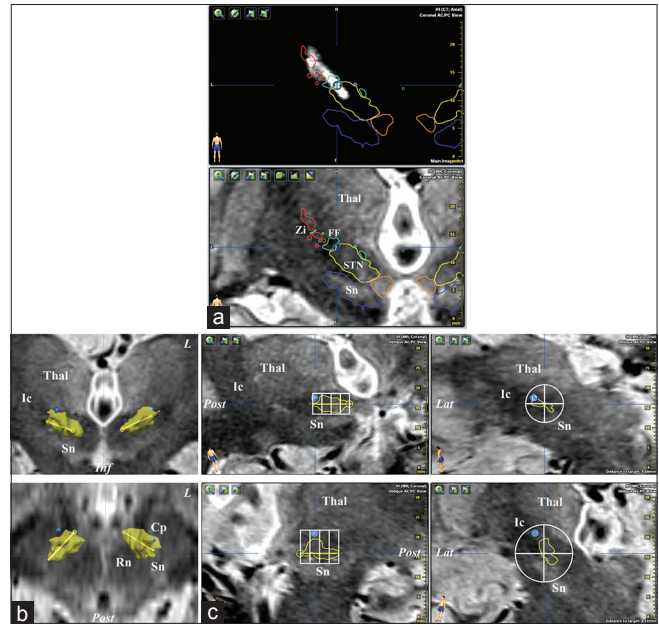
Example (patient #53, see Table 3) of effective contact location used at 1-year post-surgery (1.5 T MRI). (a) Coronal CT-scan (top) and MRI (bottom) slices (perpendicular to anterior commissure–posterior commissure line; light-green dot) running through the effective contact (blue circle; contact 1) of the left electrode (white artefact); co-registered; showing the position of the contact at the superior and lateral boundary of the subthalamic nucleus (STN).Thalamus (Thal), zona incerta (Zi), substantia nigra (Sn), and fields of Forel (FF) are shown. (b) Frontal (top; inferior, Inf) and superior (bottom; posterior, Post) views (left, L) of the right and left subthalamic nucleus (yellow): main axis of the nucleus (yellow line) and the effective contacts (blue dots) are shown; Thalamus (Thal), zona incerta (Zi), substantia nigra (Sn), and internal capsule (Ic). (c) Reconstructed images (left hemisphere, top row; right hemisphere, bottom row) along the main axis of the STN (left column; posterior, Post) and perpendicular to the axis (right column; lateral, Lat) showing contact locations according to longitudinal and transversal subdivisions (white grid) and STN membership (white circle grid): left contact, Rear longitudinal position, SupLat transversal position, and Frontier STN membership; right contact, InterAnt position, SupLat transversal position, and Out STN membership
